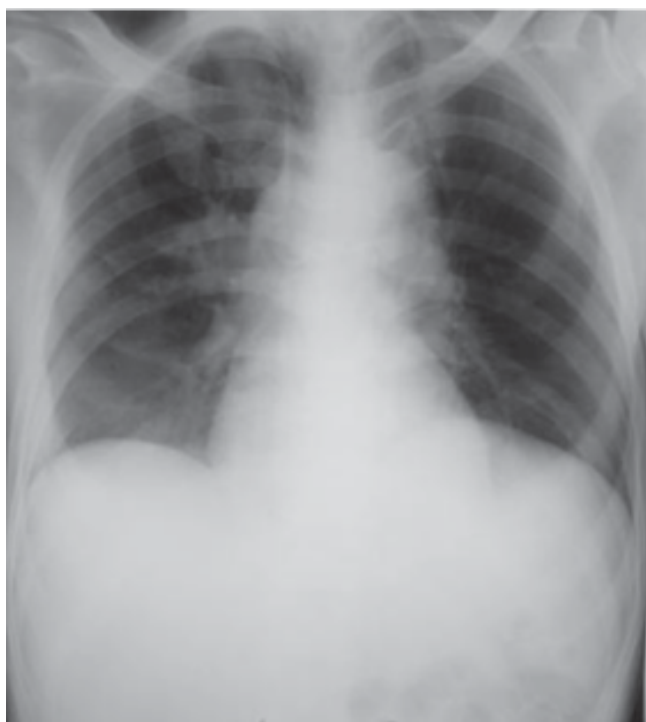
Control PA chest X-ray after antibiotics.
